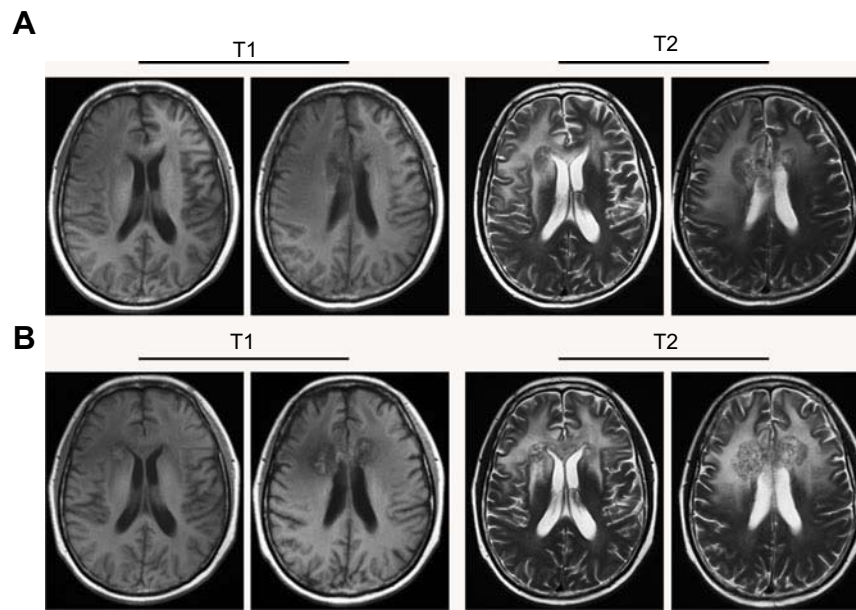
MRI scan after stereotactic radiotherapy. (A and B) After treating with mannitol and steroids to reduce intracranial pressure and to limit further damage caused by cerebral edema, an MRI scan revealed an enhanced solitary mass (53×28×20 mm) with a surrounding area of low intensity in the bilateral frontal lobe and genu of the corpus callosum. Abbreviations: MRI, magnetic resonance imaging; T1, T1-weighted images; T2, T2-weighted images.
